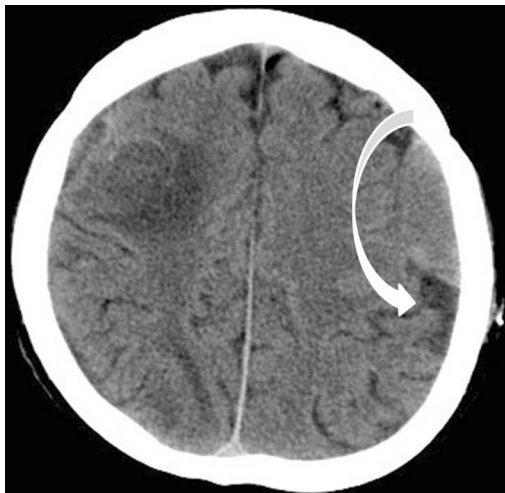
Left sided isodens lentiform image on computed tomography
